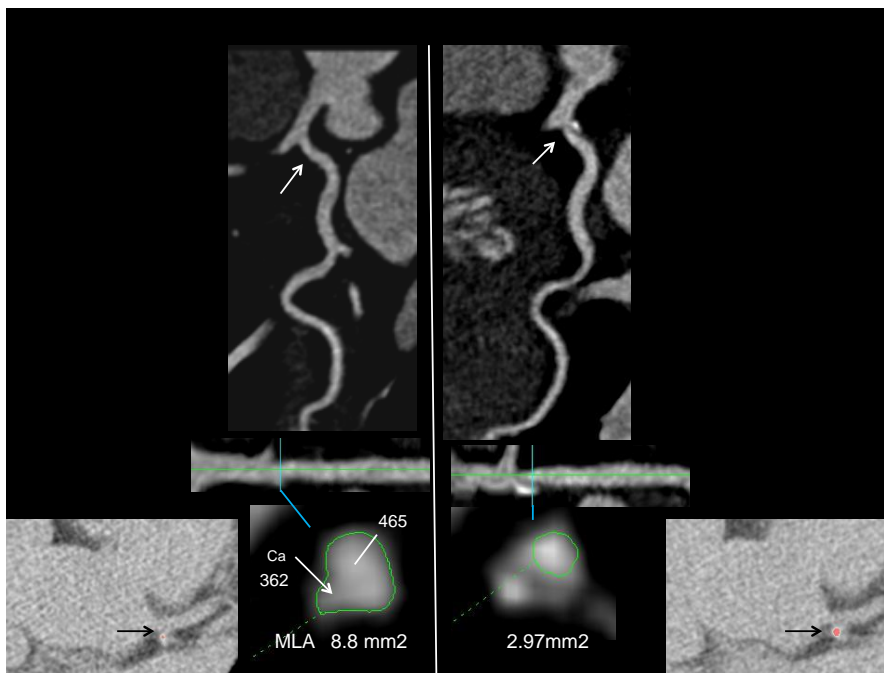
Left: MPR of LCx demonstrating mild calcified plaque confirmed on the noncontrast CT (insert). Right: 2 years later the calcified plaque has increased, with significant MLA reduction and new noncalcified plaque.
